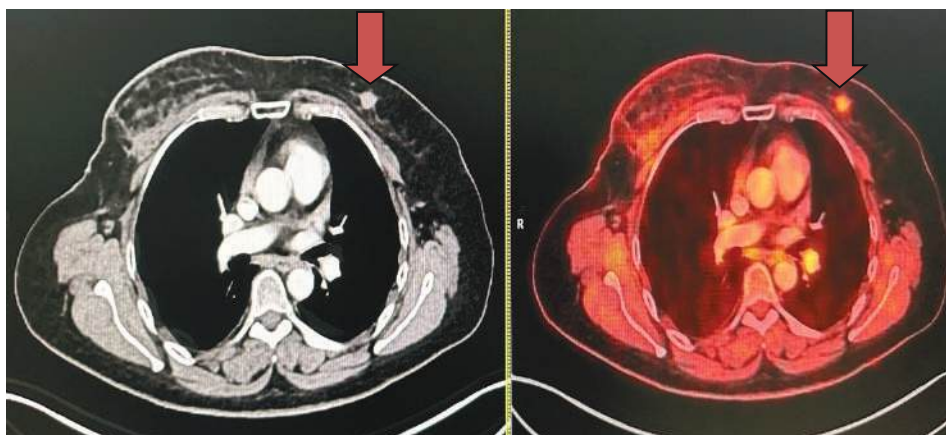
Metastasis in contralateral (left) breast from treated primary right breast cancer. FDG avid (SUV: 3.12) enhancing, irregular soft tissue density lesion is marked (red arrow) at the upper inner quadrant of left breast. Post operative and post radiation changes are also noted (Right).
